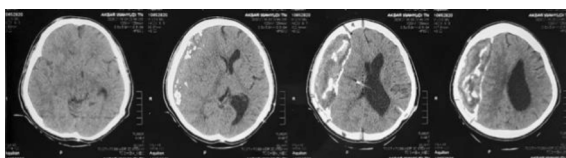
CT scan with contrast presented hydrocephalus ex vacuo and CSDH in the right frontoparietal lobe.
